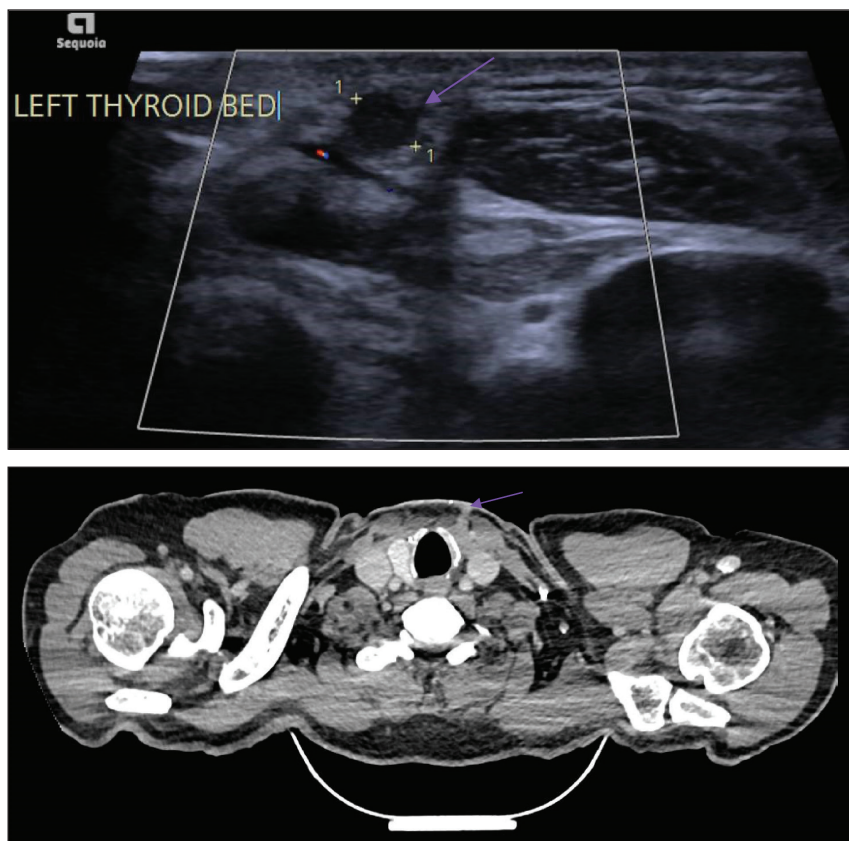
A - US suggestive of an $8 \times 10 \times 13$ mm hypoechoic nodule with microcalcification and internal vascularity. B - Axial CT demonstrating a small subcutaneous nodule just superficial to the anterior border of the left SCM.
